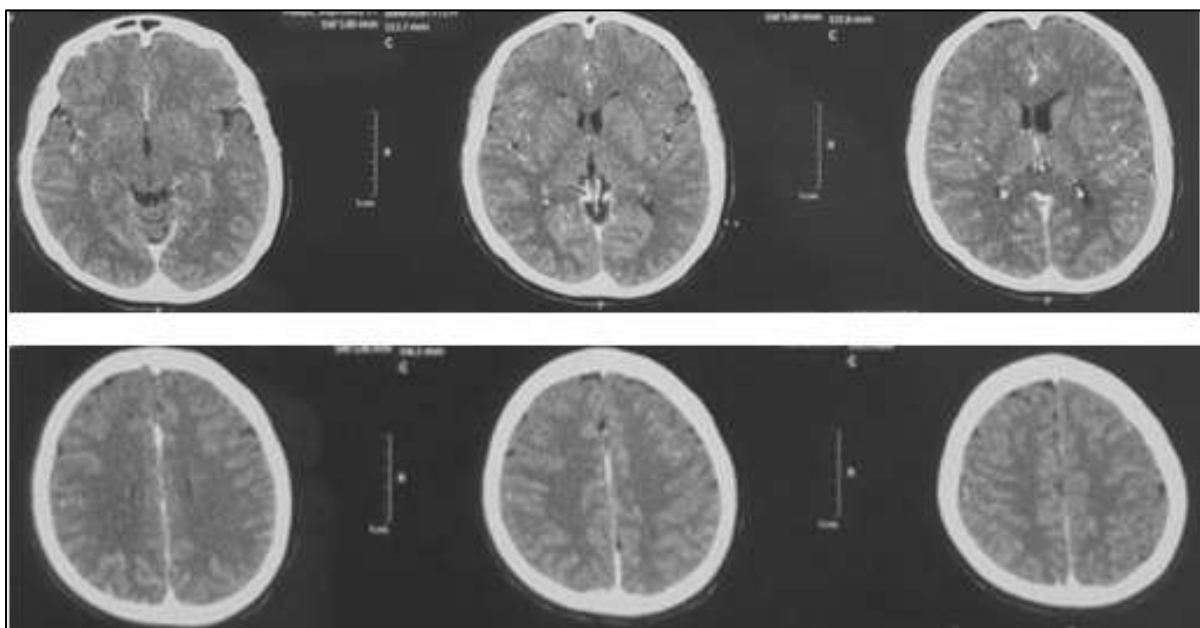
Contrast Head CT scan shows no evidence of acute infarction or Transient Ischemic Attack (TIA). No signs of space-occupying lesions (SOL) or intracranial hemorrhage were observed.
